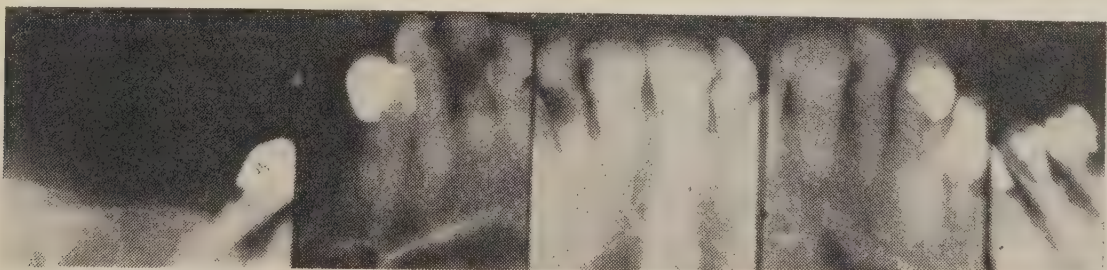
Radiographs showing rampant dental caries in an elderly woman with a very dry mouth. She also indulged too freely in sweets.
